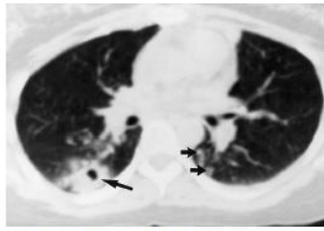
32-year-old woman with bronchocentric granulomatosis. CT (5 mm collimation) reveals a 2 cm cavitating mass in the superior segment of the right lower lobe (large arrow). Also noted are small nodules in the superior segment of the left lower lobe (small arrows).
